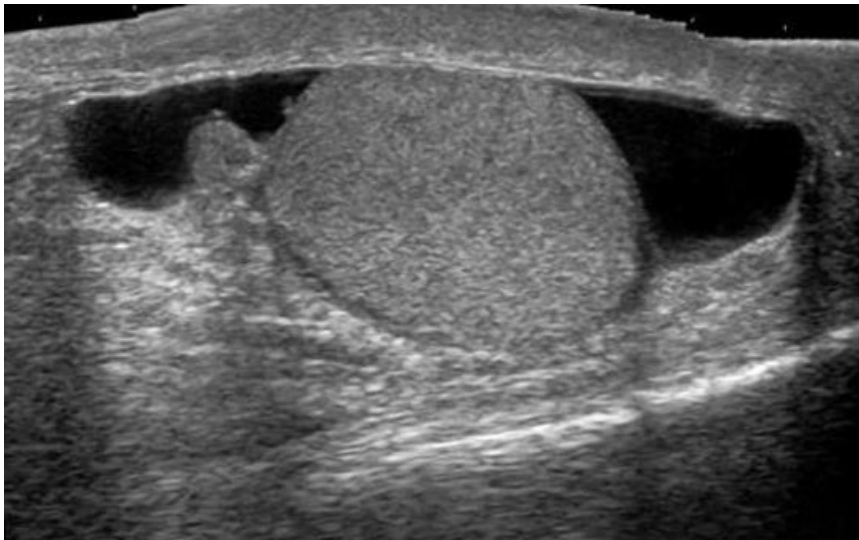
High-resolution ultrasound of the scrotum reveals appendages of the upper pole of the testis (*Sellrs, 2003*).
